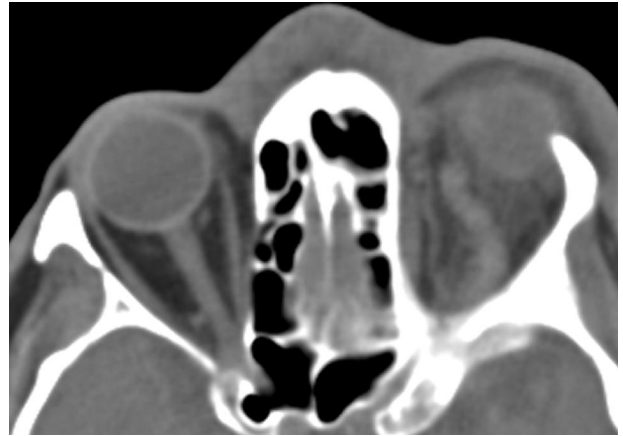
Orbital CT with left-sided orbital inflammation and dilated superior ophthalmic vein.
